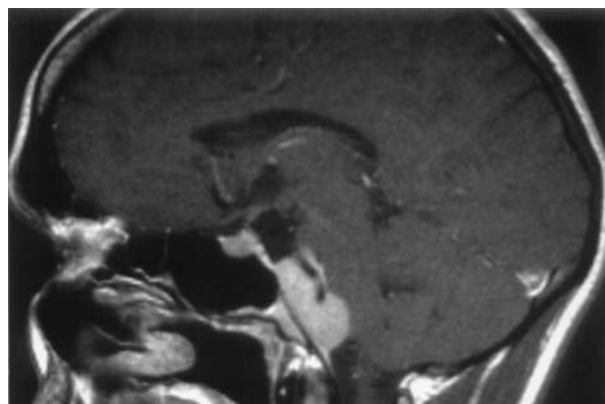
Post Gadolinium T1-weighted MR image obtained at the time of radiosurgery. Note the close relationship of the midclivus meningioma with the ventral brainstem and involvement of the basilar artery
